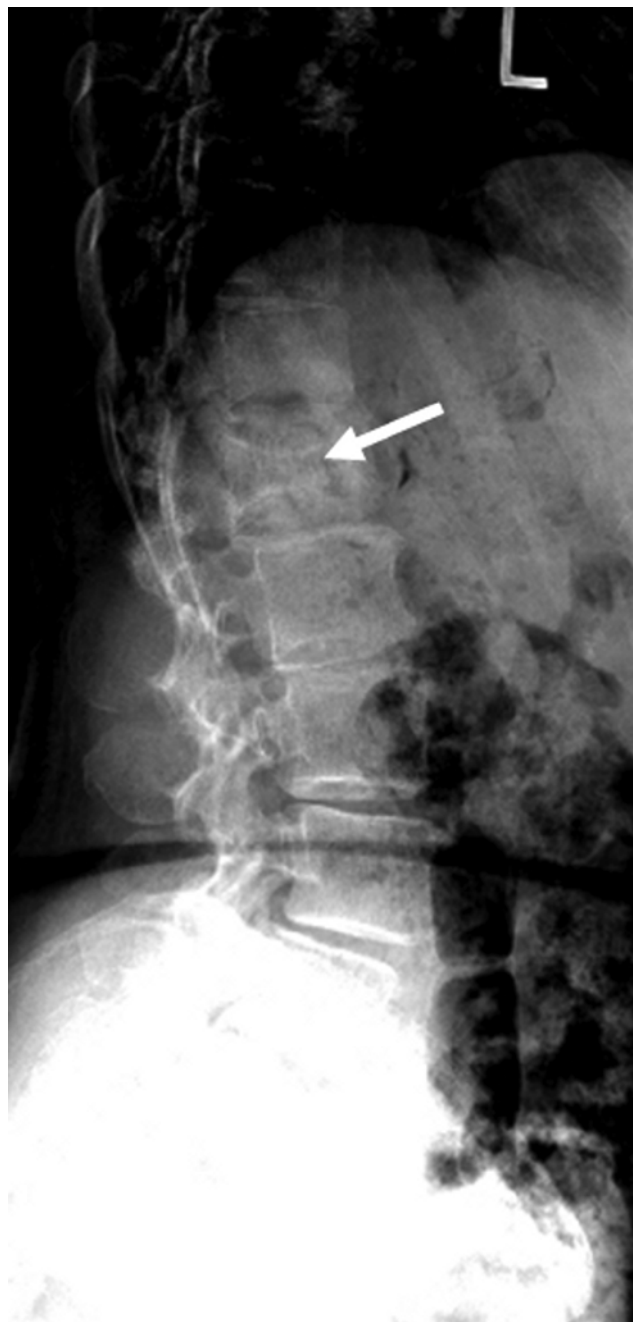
Lateral radiograph of a patient who presented for evaluation of lumbar radiculopathy, in whom a loss of vertebral height was encountered incidentally (arrow). A CT scan revealed changes consistent with Paget disease.
